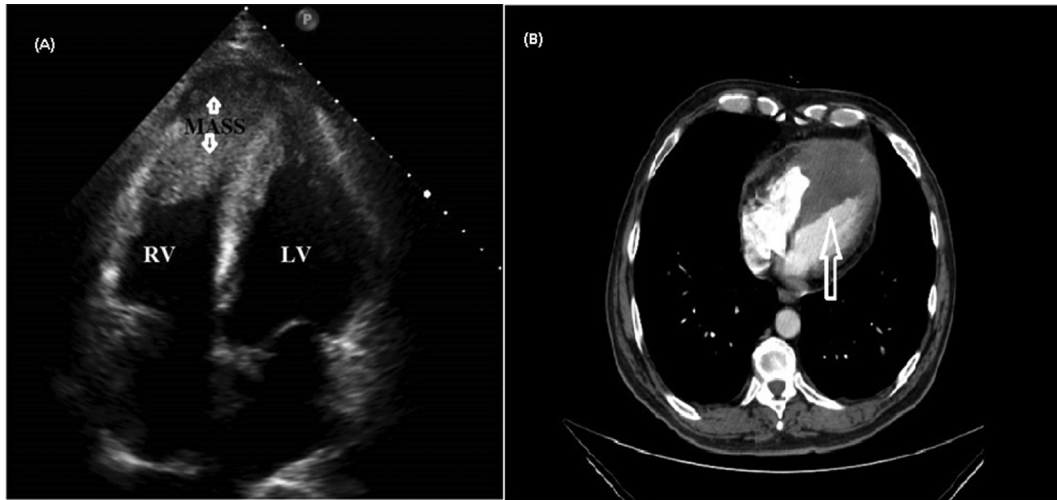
(A)The apical 4-chamber plane showed a RV mass that was 45 × 32 cm in size (arrows). (B) Contrast-enhanced CT scans (axial view). Mass was found in the right ventricular chamber.
